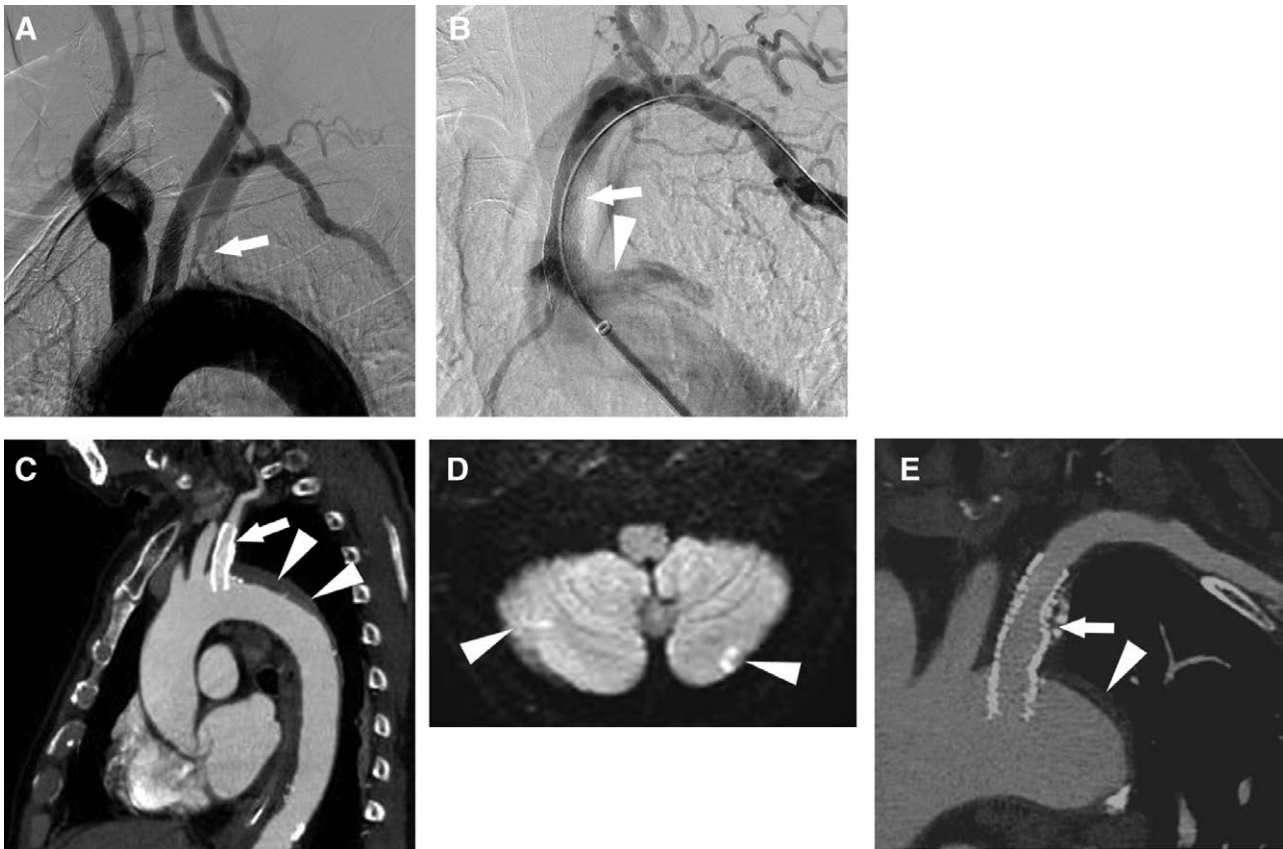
A–E, PTAS for the stenosis of the left SA complicated by type B aortic dissection. This 76-year-old male patient had medically refractory syncope and dizziness. The angiogram showed 85% stenosis of the left proximal SA (A, arrow). After predilatation with a 7 mm balloon, a 9 × 37 mm balloon-expandable Express LD stent was deployed in the left proximal SA (B, arrow). The control angiogram revealed type B aortic dissection (B, arrowhead). Contrast-enhanced CT of the chest on the following day demonstrated aortic dissection (C, arrowheads). MRI of the brain on the next day also showed small recent embolic infarcts in the bilateral cerebellar hemispheres (D, arrowheads). Follow-up CTA of the neck 1 month later showed obliteration of the aortic dissection (E, arrowhead). Note that the stent migrated proximally after resolution of the intramural hematoma (E, arrowhead). CTA = computed tomography angiography; MRI = magnetic resonance image; PTAS = percutaneous transluminal angioplasty and stenting; SA = subclavian artery.
